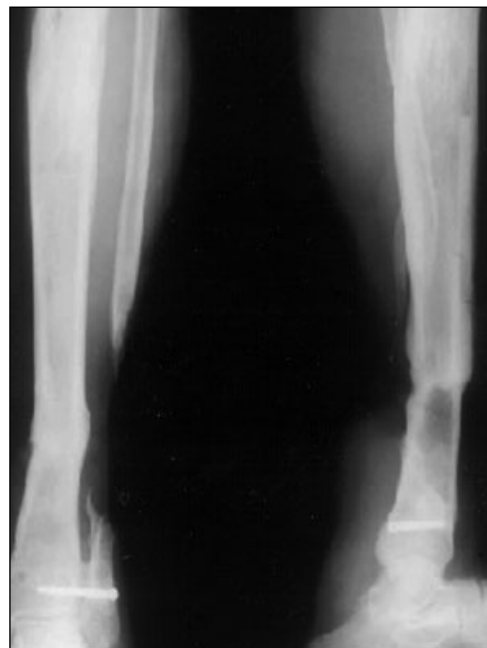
Radiograph at 1.5 year follow up, showing union of the fracture, lengthening of tibia and 7 arthrodesis of the distal tibio-fibular joint
